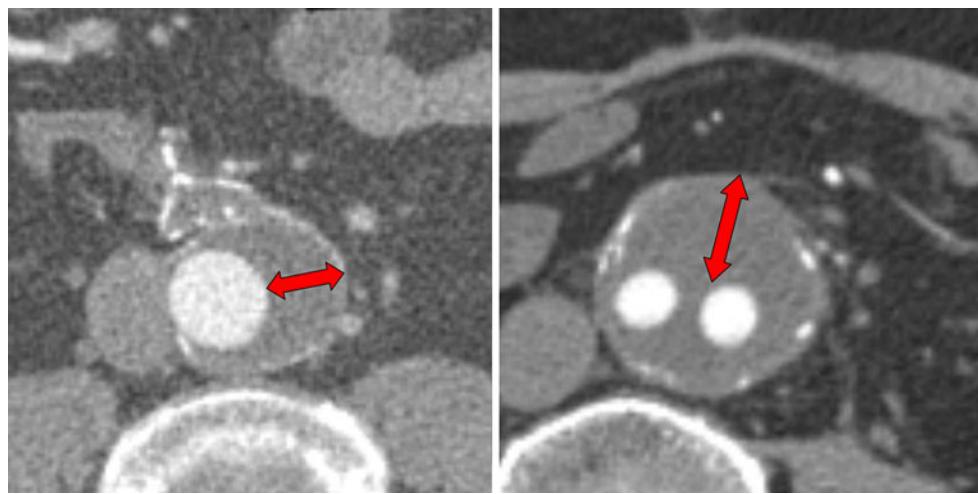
Measurement of perigraft fluid width on CT scans. The maximum width of perigraft fluid on any axial section was identified. In case of a bifurcated graft, the maximum distance between the tangent to the two graft limbs and the aneurysm sac wall was measured
